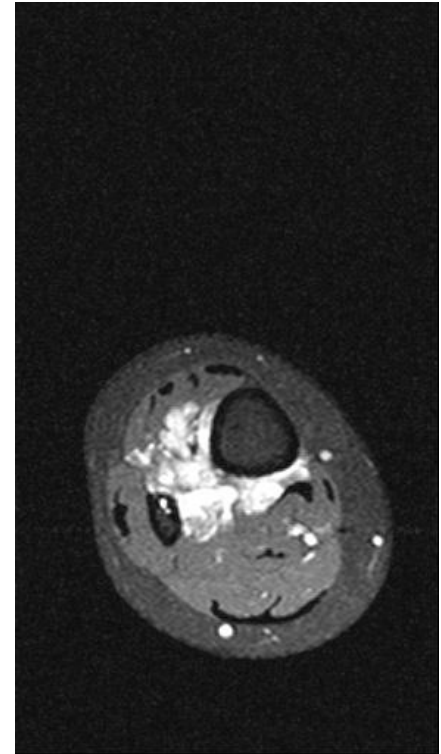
Haemangioma. MRI shows characteristic serpiginous high signal which insinuates around soft tissue structures. The phleboliths seen on the x-ray are surprisingly difficult to
